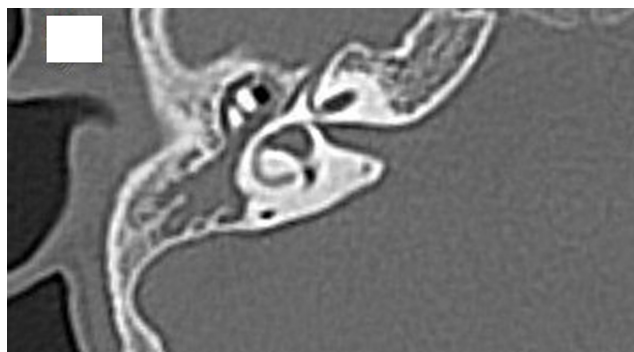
An axial cut of right temporal bone HRCT, showing opacification of the middle ear cleft (it was scored 1 mark). HRCT, high-resolution CT scan.
